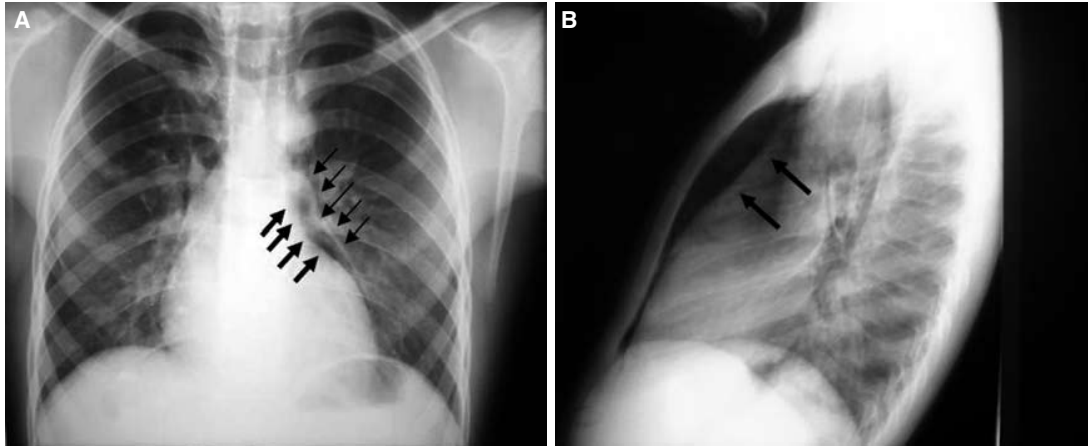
(A) Posteroanterior and (B) left lateral chest radiographs showing the presence of air in the anterior mediastinum.
